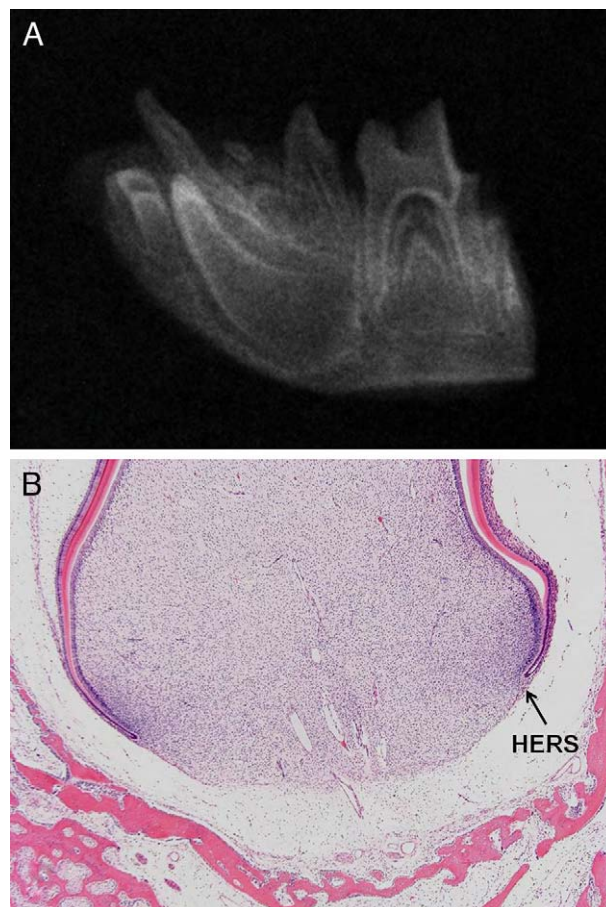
(A) Radiographic image of mandibular left quadrant of 36-day-old ferret demonstrating a retained deciduous cuspid tooth and the unerupted permanent cuspid. (B) Histophotographic image of mandibular left cuspid of 36-day-old ferret. Inner and outer enamel epithelia can be visualized giving rise to HERS. In addition, dental papilla, odontoblastic layer, developing dentin and enamel organ are visible at this stage of this tooth development.
